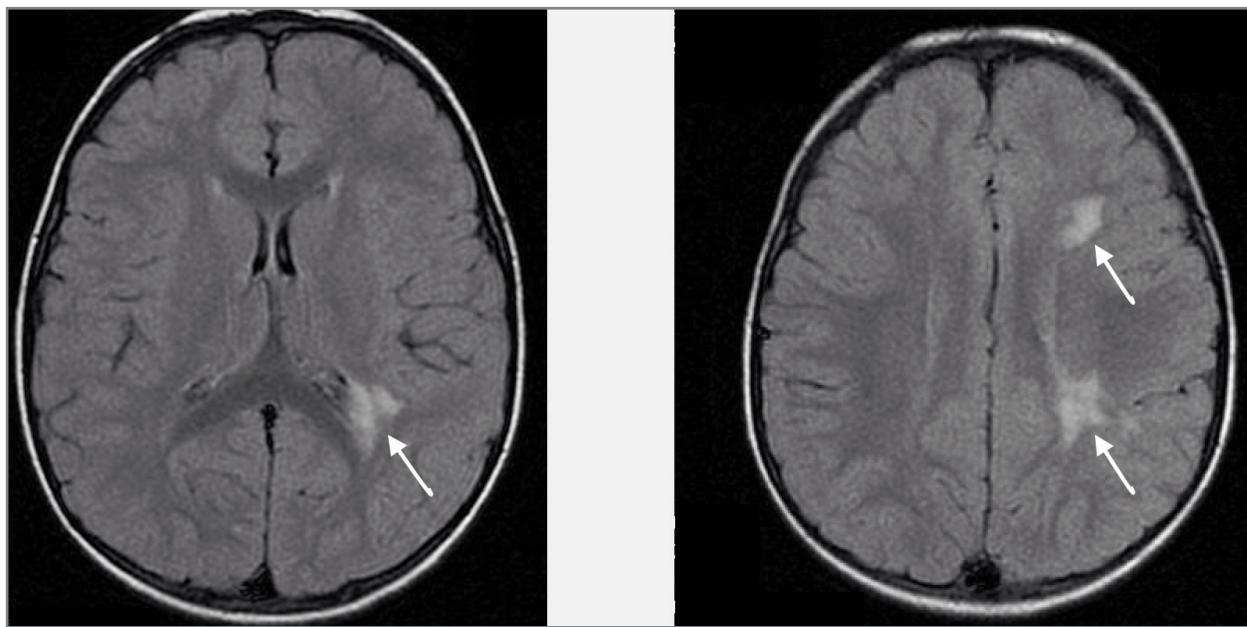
T2 Flair MRI images at diagnosis showing subcortical periventricular and frontal-parietal hyperintense lesions in the left lobe.
